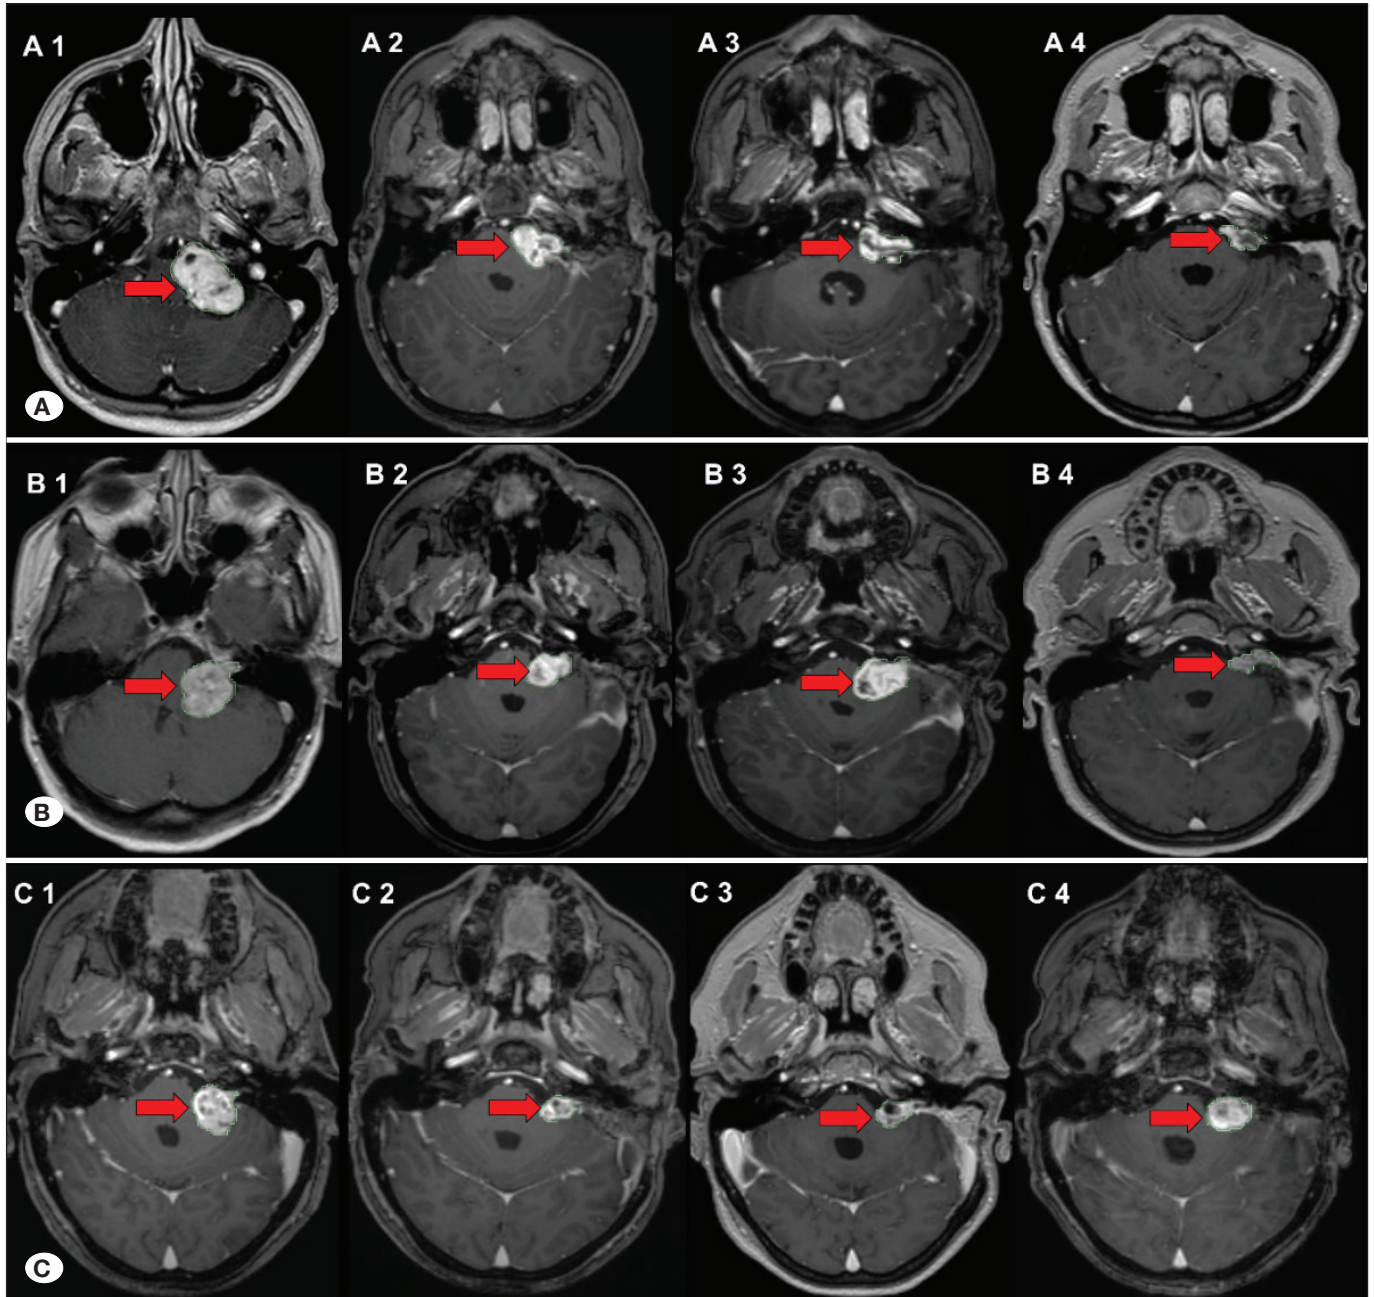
Transverse T1 3D MRI scans with gadolinium contrast in three patients (A, B, C) with left sided VS, representing tumour shrinkage (A), transient swelling followed by shrinkage (B), and progression (C). 1 = pre-operative tumour, 2 = tumour before Gamma Knife, 3 = tumour 15 months after Gamma Knife, 4 = last follow-up.
